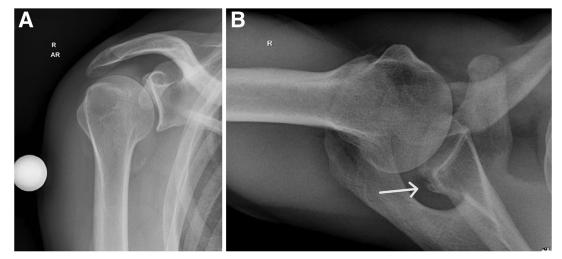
Preoperative radiographic imaging of right shoulder: anteroposterior (A) and axial (B) views. The mis-healed bone fragment (arrow) can be seen at the posterior part of the glenoid. AR, external rotation; R, right.
